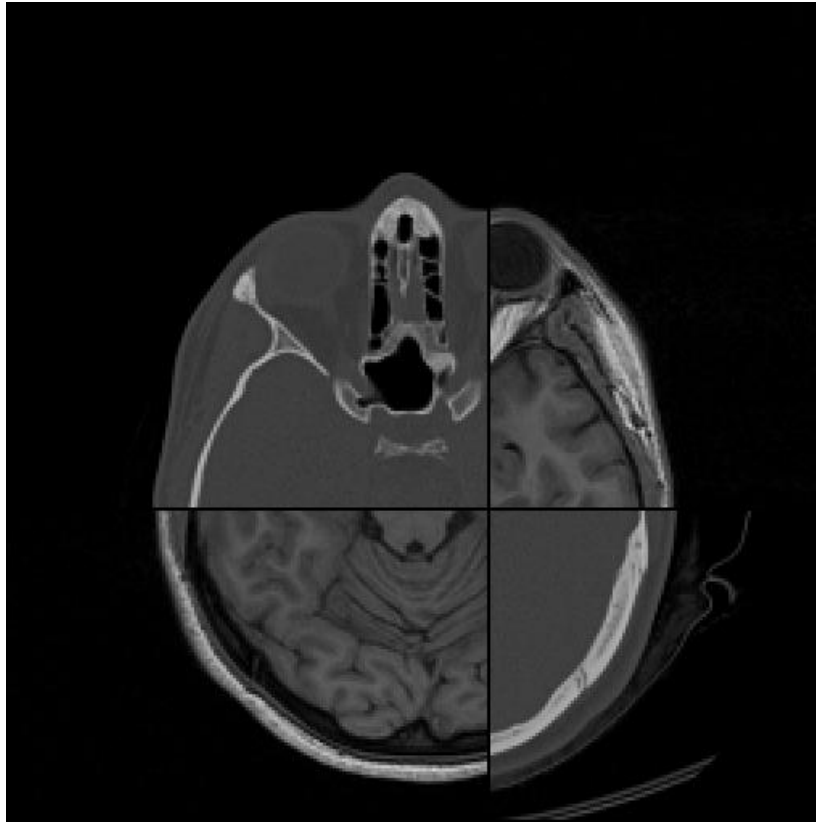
MR (top right, bottom left) and CT (top left, bottom right) images are shown together after registration
